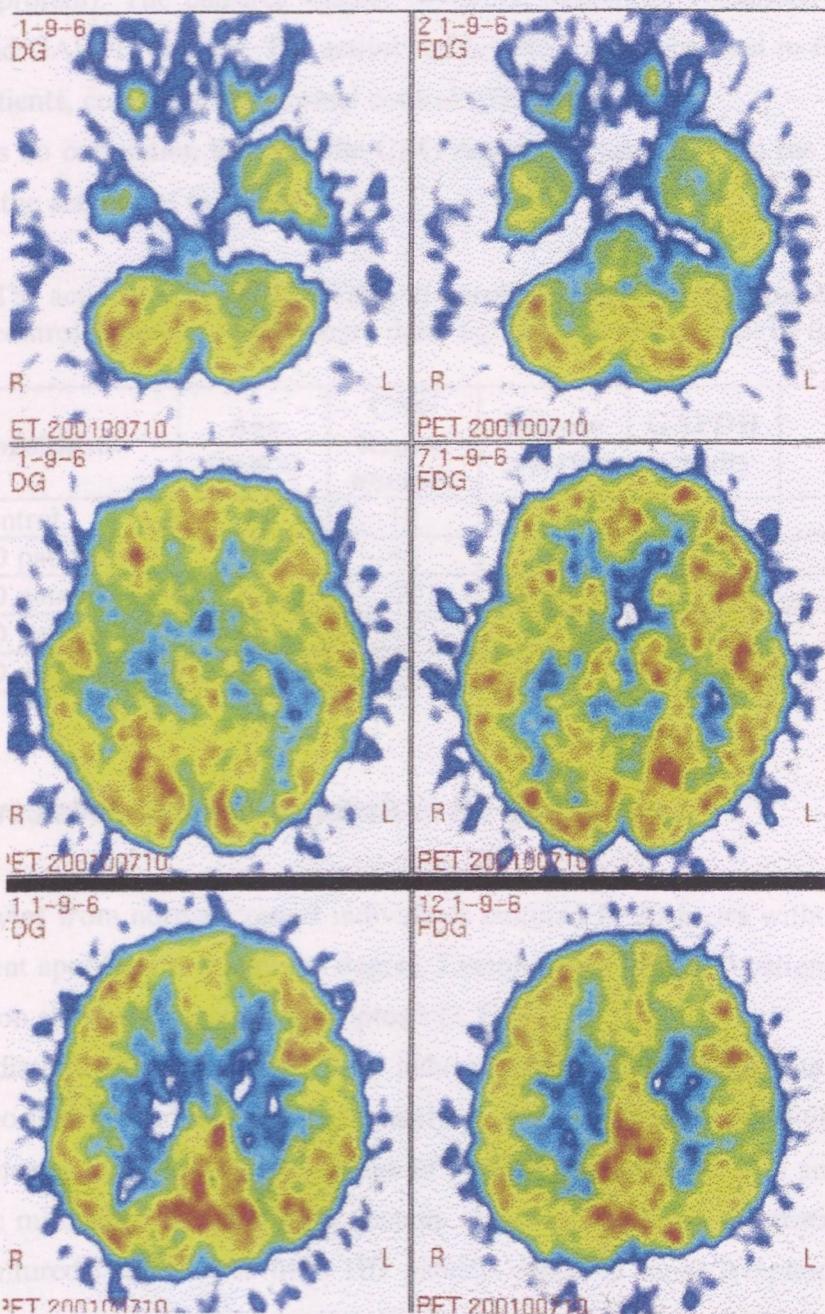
[(18)F]FDG-PET picture of the 44 years old asymptomatic carrier with 45 CAG repeats showed reduced [(18)F]FDG uptake asymmetrically in the striatum
